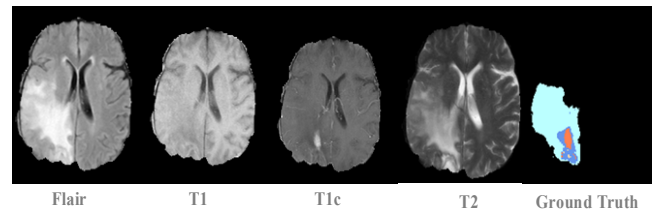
An MRI example of a tumor patient
